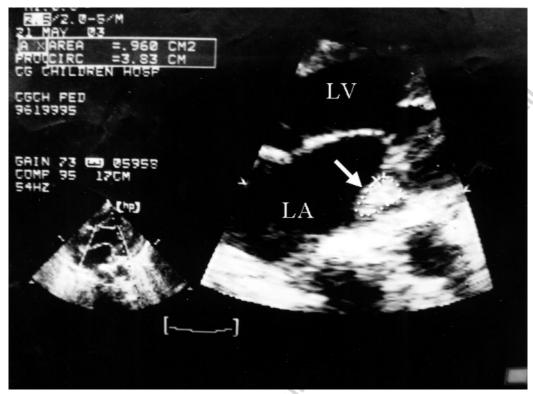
Transthoracic echocardiography showed a vegetation (arrow) on the insertion of the posterior leaflet of the mitral valve on the left atrial side.
